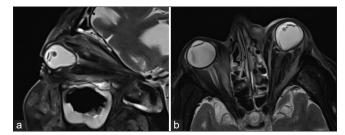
(a and b) Sagittal and coronal MRI T2 images show posterior globe tenting, also called a guitar pick sign, in orbital compartment syndrome as well as the involvement of the premaxillary region
